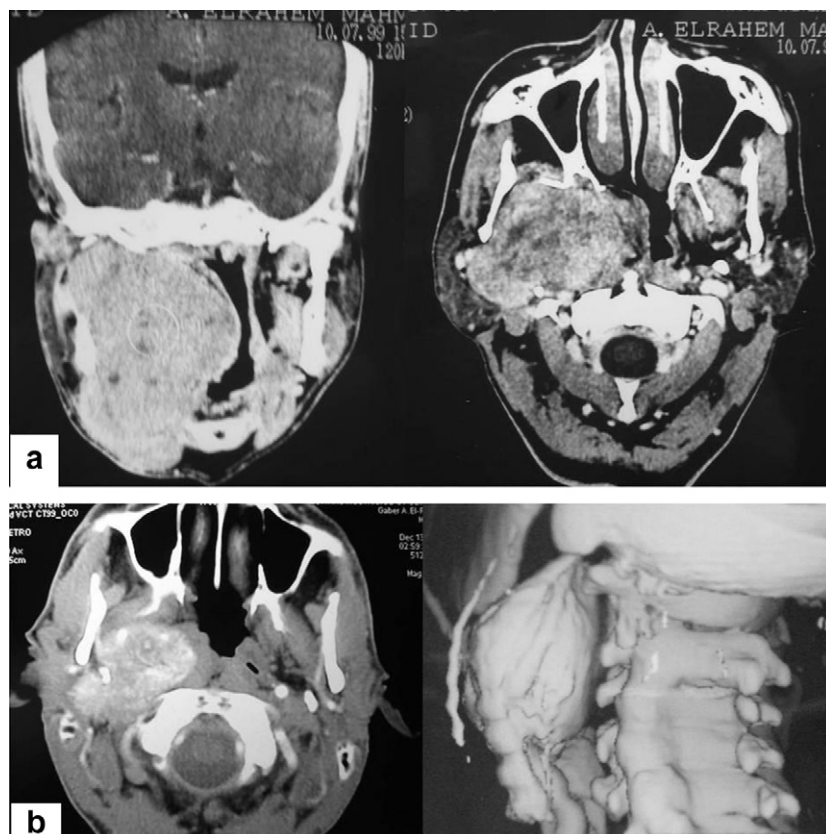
CT scans of patients with: (a) pleomorphic adenoma; (b) carotid body tumor.
